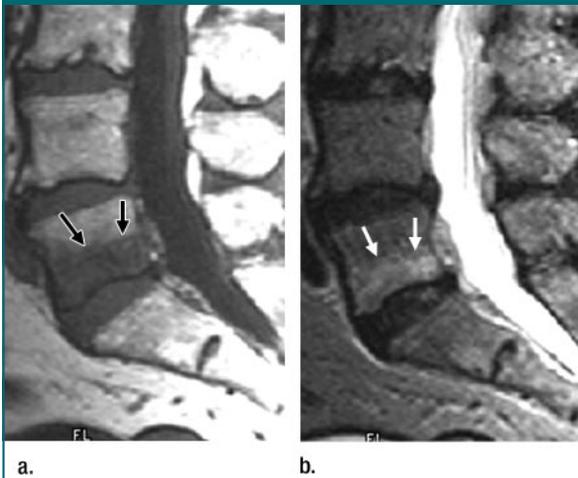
Degenerative type I marrow change. (a) Sagittal midline T1-weighted SE (450/12) image demonstrates decreased signal intensity of marrow space adjacent to L5-S1 disk (arrows). (b) T2-weighted SE (4000/120) image in the same region (arrows) shows increased signal intensity.
